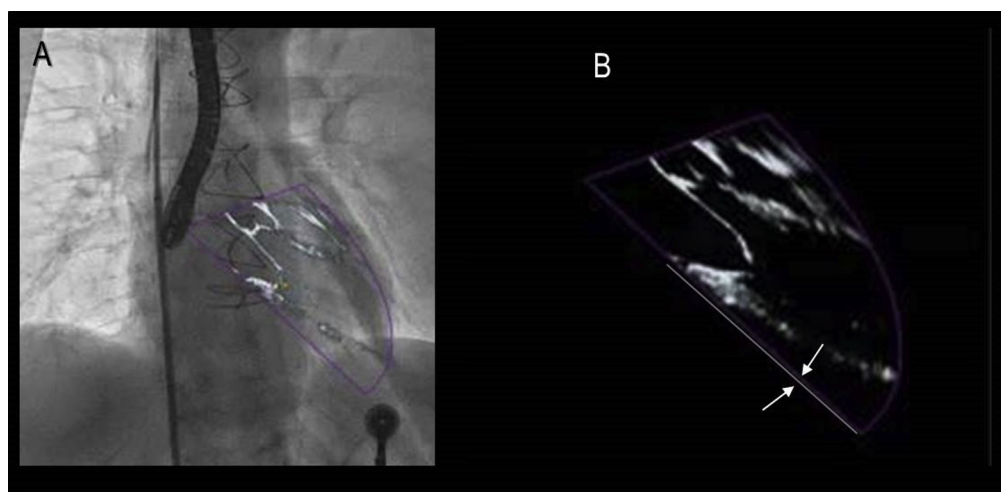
(A) Fluoroscopic-echocardiographic fusion imaging in which the transesophageal echocardiographic long-axis view is visualized within the fluoroscopic silhouette of the heart in anteroposterior projection. (B) The same magnified image without fluoroscopy. The thinness of 2D cross-sections (arrows) can be appreciated.
